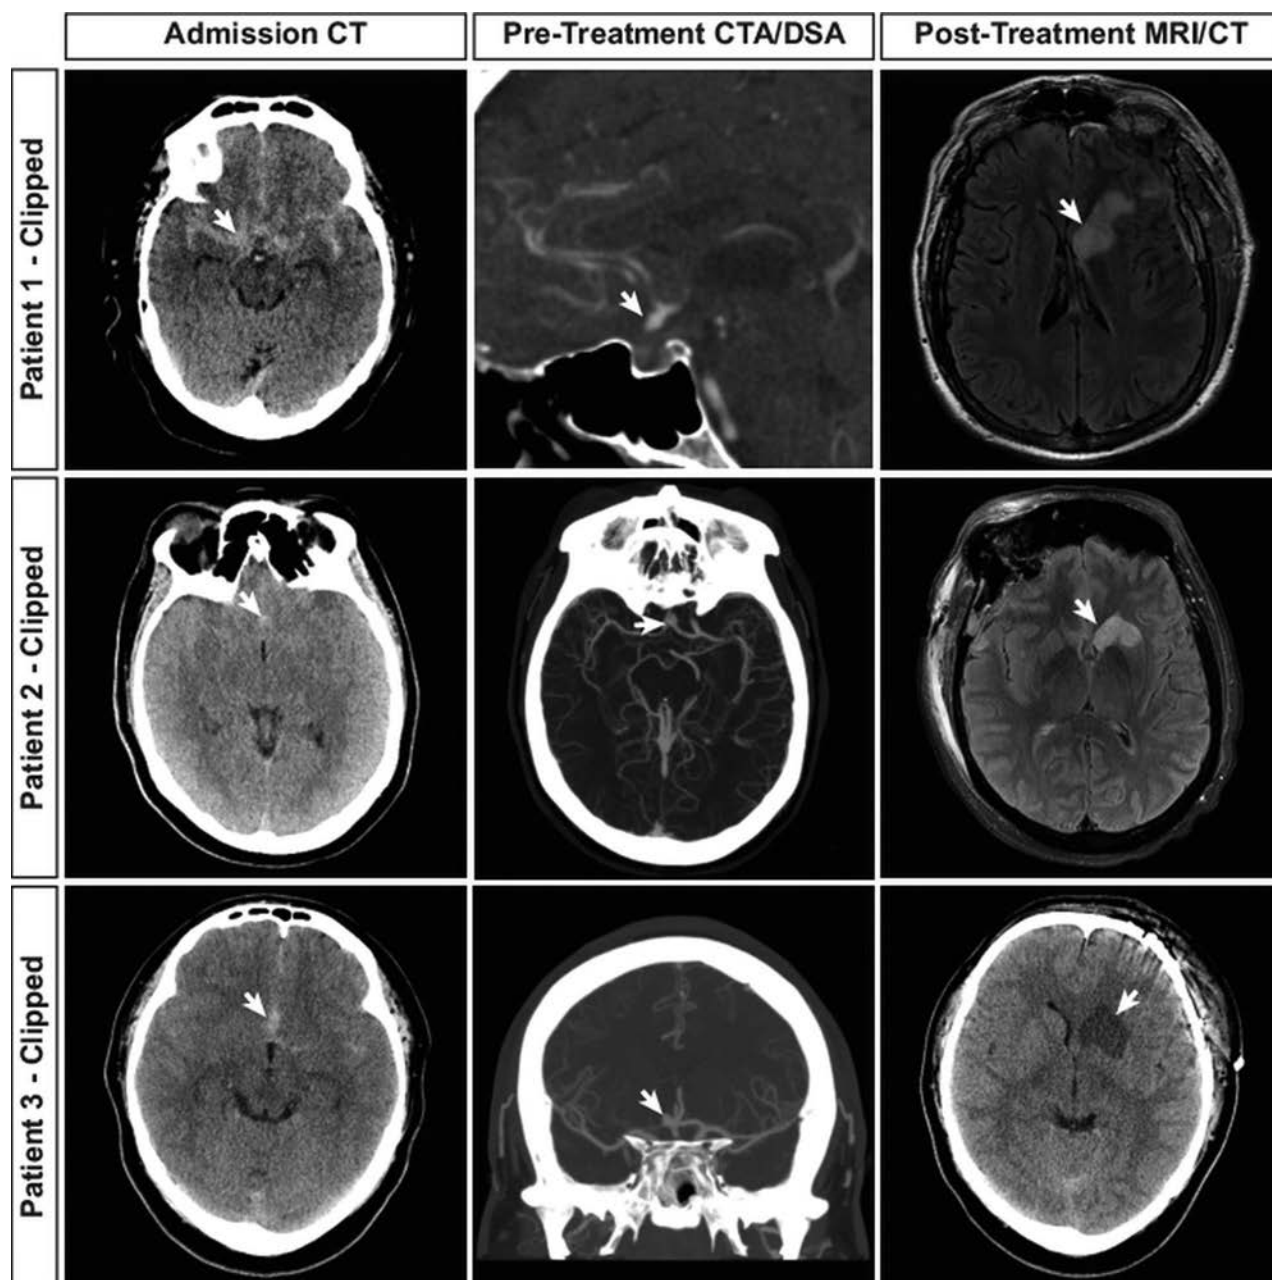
Recurrent artery of Heubner infarction in patients with ruptured AcomA treated by microsurgical clipping. Neuroimaging studies from 3 patients with ruptured AcomA treated by microsurgical clipping are shown. Admission head CT shows SAH (arrows, first column) as hyperattenuated blood in the subarachnoid space. Vascular imaging demonstrates the AcomA (arrows, second column) in each patient by CTA. Postclipping neuroimaging demonstrates cerebral infarction in the RAH territory (arrows, third column) by fluid-attenuated inversion recovery MR imaging (patients 1 and 2) or NCCT (patient 3).
